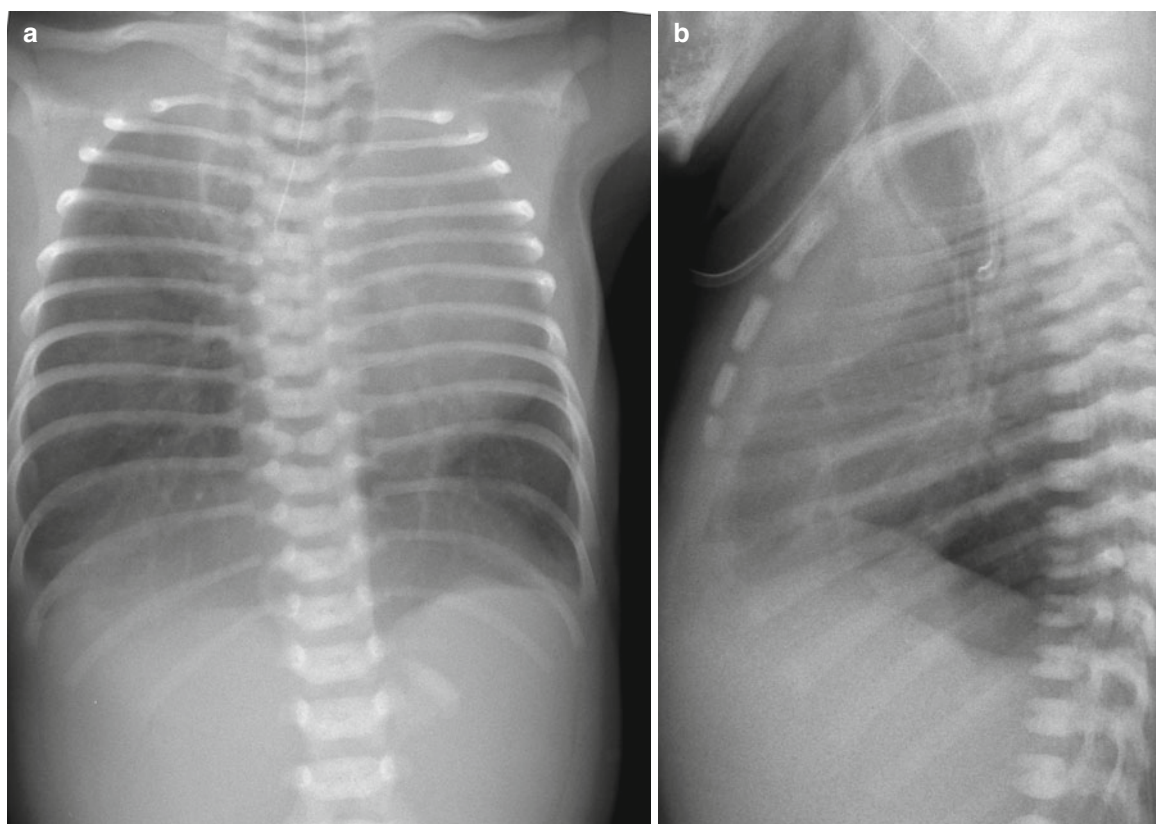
Esophageal atresia without tracheoesophageal fistula in a 1-day-old neonate with high-type imperforate anus. (a) Chest radiograph shows a radiopaque tube curling in the distended proximal esophageal pouch and gasless abdomen indicating lack of a distal TEF. Note
